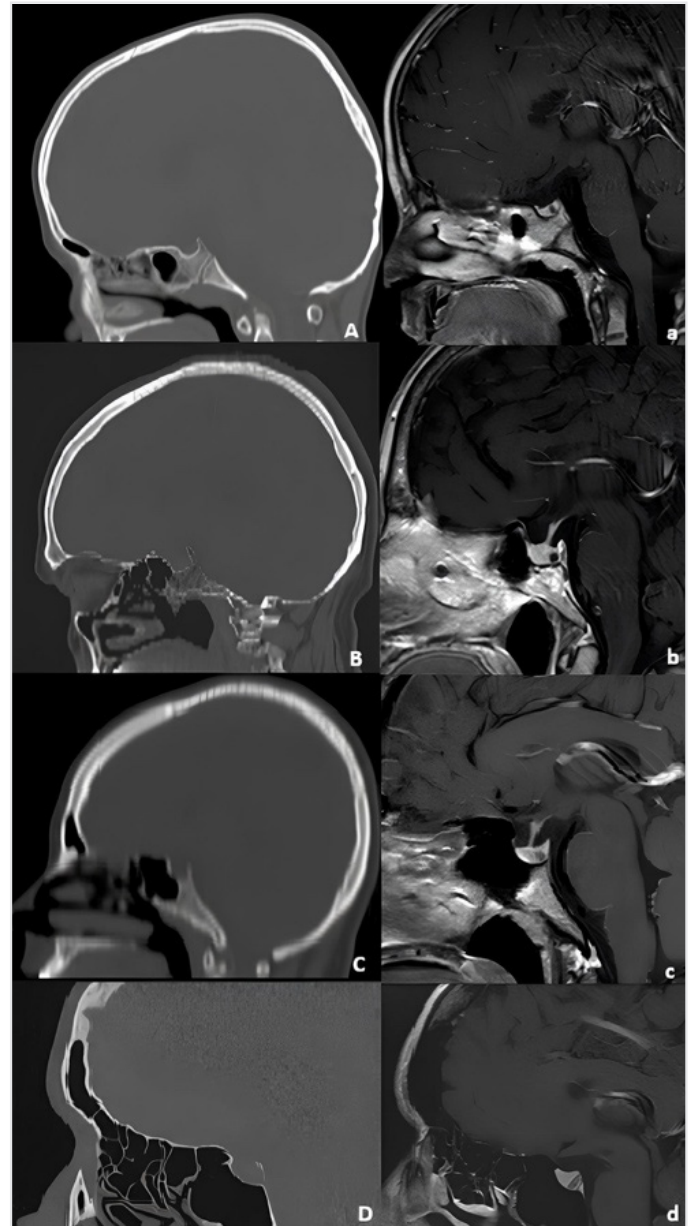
Representative sagittal computed tomography (left column) and corresponding magnetic resonance imaging (right column) images demonstrating the four primary sphenoid sinus pneumatization subtypes in patients with Rathke's cleft cyst. (A, a) Conchal type: minimal aeration anterior to the sella; (B, b) presellar type: aeration extending anteriorly but not reaching the sella; (C, c) incomplete sellar type: partial pneumatization beneath the sella turcica; (D, d) complete sellar type: extensive pneumatization extending fully below the sellar floor
